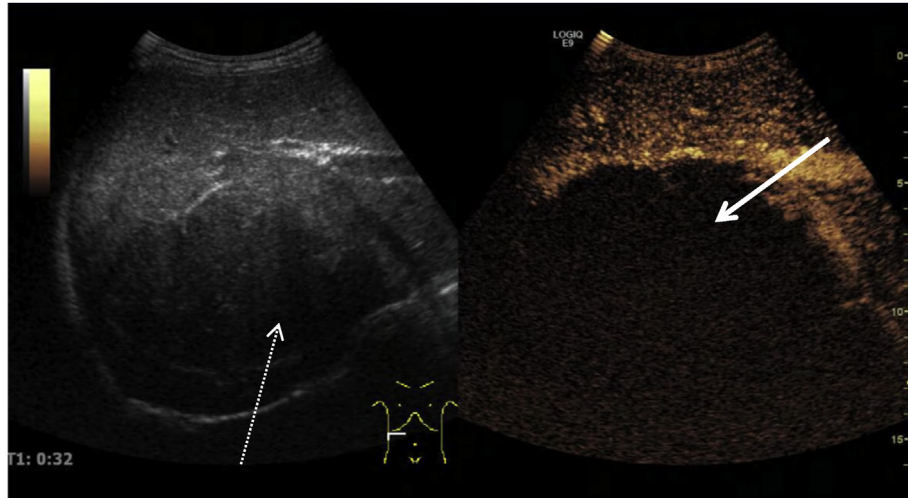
Ultrasound image showing mixed lesion (Dotted white arrow) in the right posterior lobe of the liver combined with contrast-enhanced ultrasound image showing hepatic alveolar echinococcosis (White arrow) with surrounding activity.
